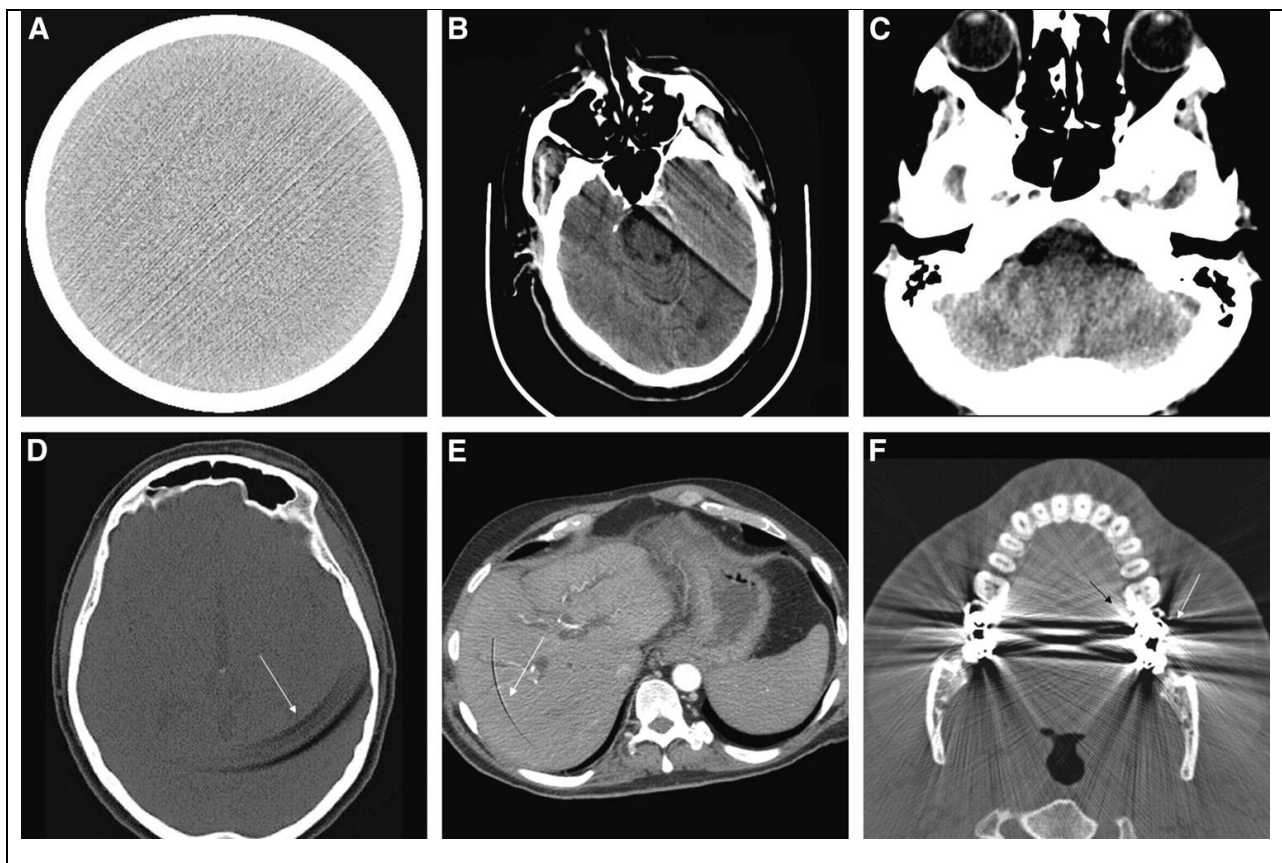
Examples of CT artifacts: streak artifact (A), motion artifact (B), beam-hardening artifact (C), ring artifacts (D and E), and metal artifacts (F) [16].
